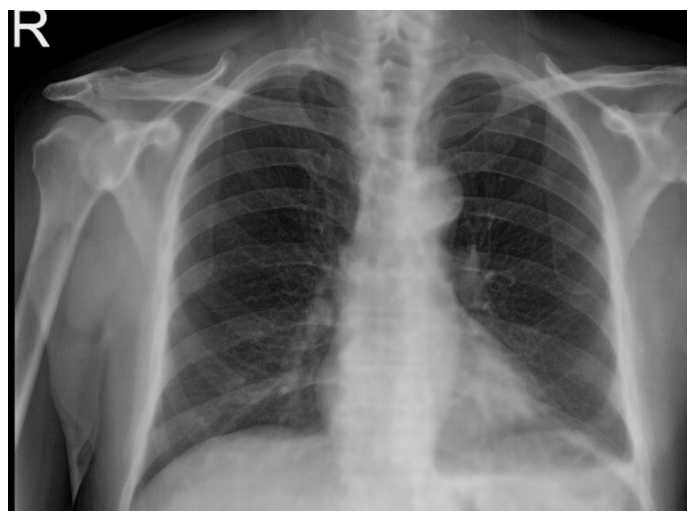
Regression in pleural effusion on chest X-ray before discharge
